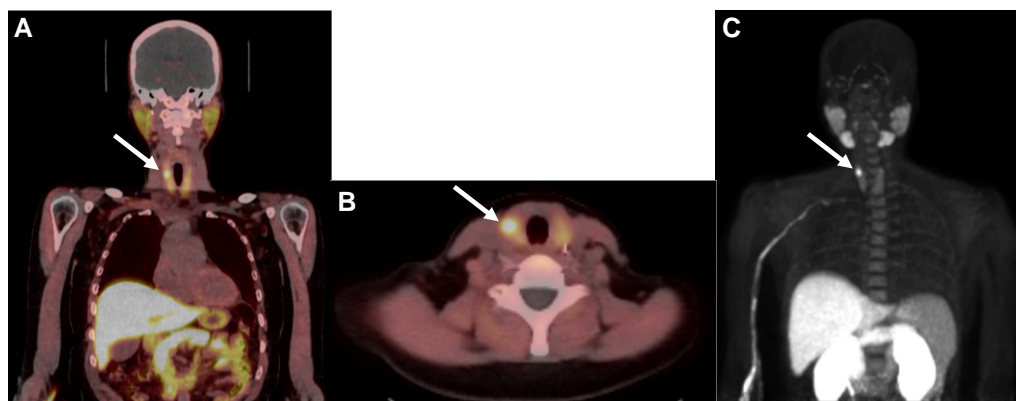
^{18}F -Fluorocholine positron emission tomography/computed tomography (^{18}F -FCH PET/CT) images demonstrating intense avidity of right intra-thyroidal parathyroid adenoma as highlighted by arrows. A, Fused coronal. B, Fused axial. C, Maximum-intensity projection.
